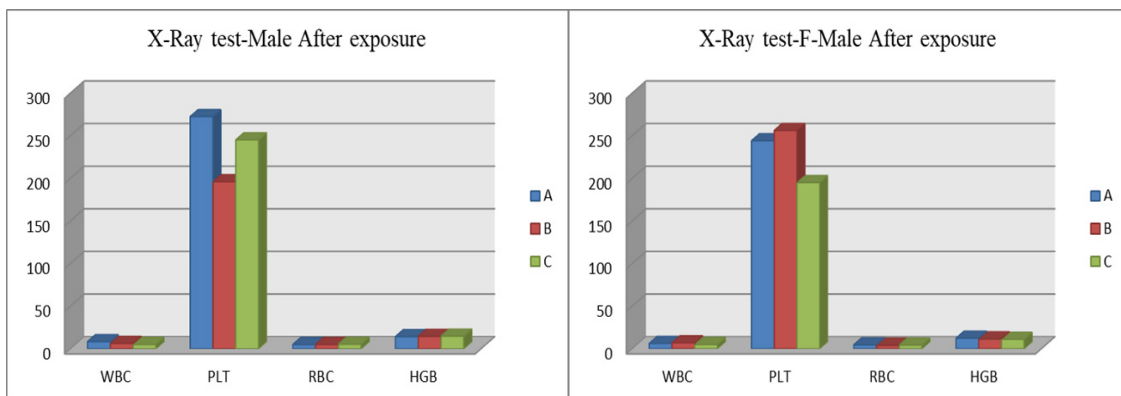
X-ray test Male & Female after exposure.
